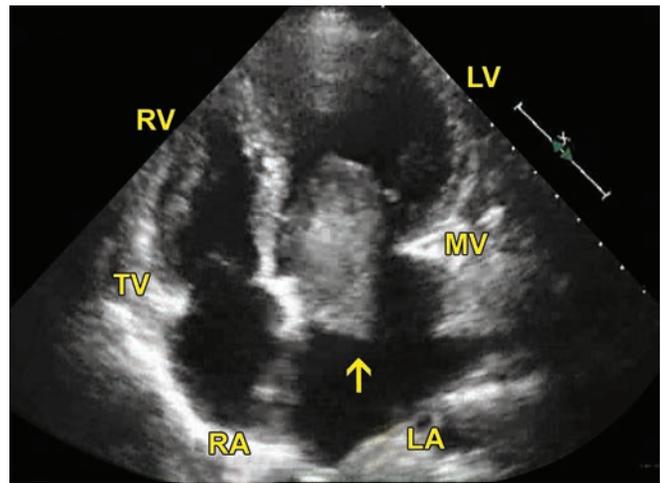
Transthoracic echocardiography. Apical four chamber view. (LA: Left atrium; LV: Left ventricle; RA: Right atrium; RV: Right ventricle). Arrow points to a large mass within the left atrium and protruding into the left ventricle.
